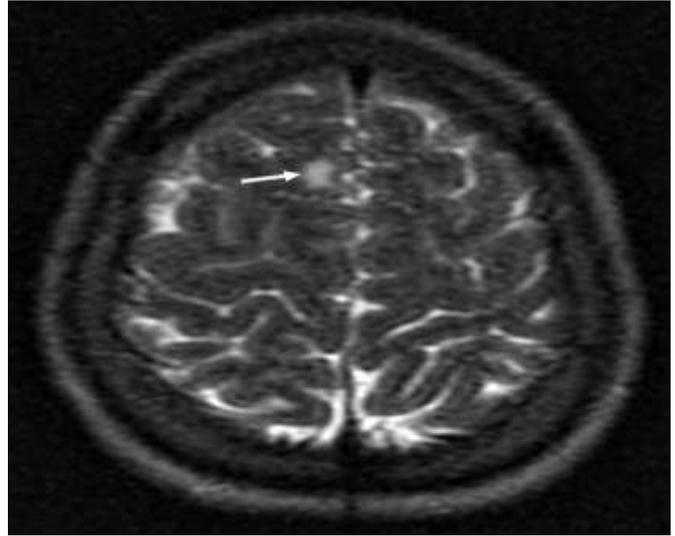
Axial T2-Weighted brain MRI showing a hyperintense focus (arrow) due to a cortical tuber in the right frontal lobe.
